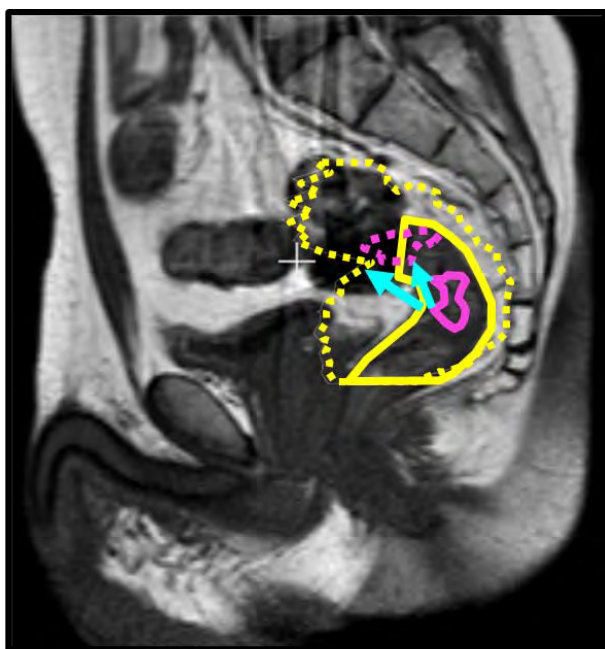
Rectum (yellow) and tumor (purple) delineations overlaid on sagittal MRI scan. The dashed delineations are from a different day. Note the difference in motion direction and extent between rectum and tumor (cyan arrows).
